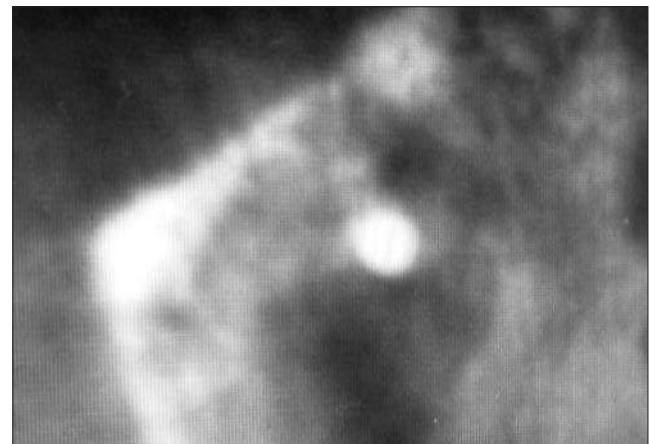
Cone-beam computed tomography images after 40 months of loading, planned for other reasons, with implant apex fully embedded into bone and stability of peri-implant bone.
